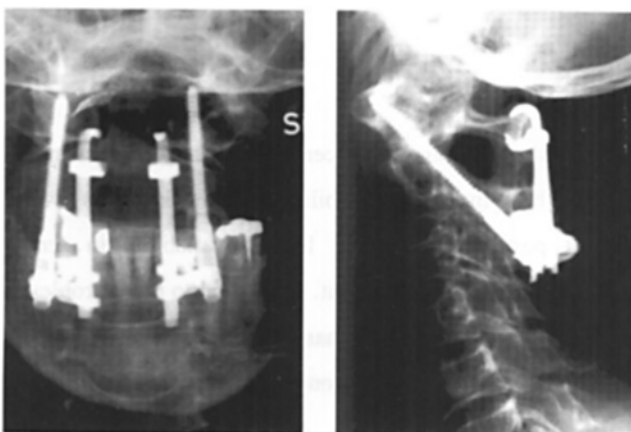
The C1-claw device combined with transarticular screws and autologous bone chips graft were used to treat this patient (#27) who had both rheumatoid arthritis and an odontoid fracture. The one year follow-up radiographs reveal a mature posterior fusion mass.
